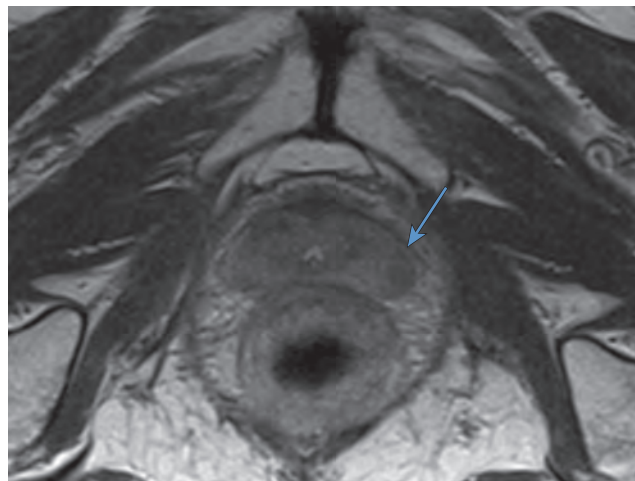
A 72-year-old man who had radiotherapy 6 years before presentation. His original disease was low risk. Biochemical failure occurred with a PSA of 3 ng/mL and rising. Multiparametric magnetic resonance imaging (mpMRI) (T2-weighted, diffusion-weighted, dynamic contrast-enhanced) showed left localized unilateral disease confirmed on template prostate mapping biopsy as unilateral Gleason 3+4 with some radiation effect. Bone scan and positron emission tomography/computed tomography were clear for metastases. Here the T2-weighted scan is shown.
